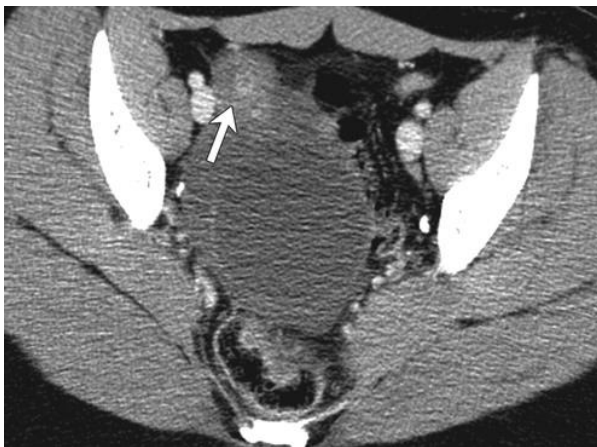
Figure # 10. CT findings of the same patient as in the figure # 9
